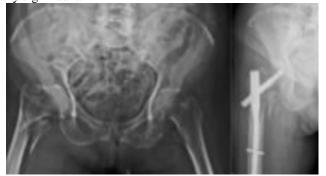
Pre-operative and postoperative first-year radiographs of an 83-year-old patient who underwent PFNA.
